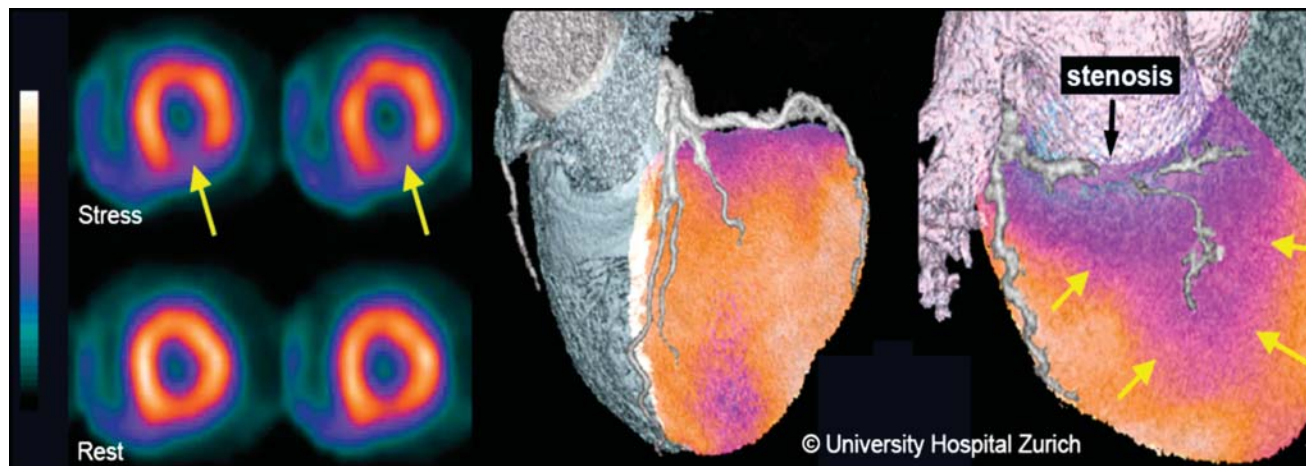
Co-Image of the Year. Left: Myocardial perfusion SPECT of ischemia at stress (top) and rest (bottom). Right: Software fused image of combined ^{99m}Tc -tetrofosmin SPECT and 64-slice CT angiography in the evaluation of functionally relevant coronary stenoses.
